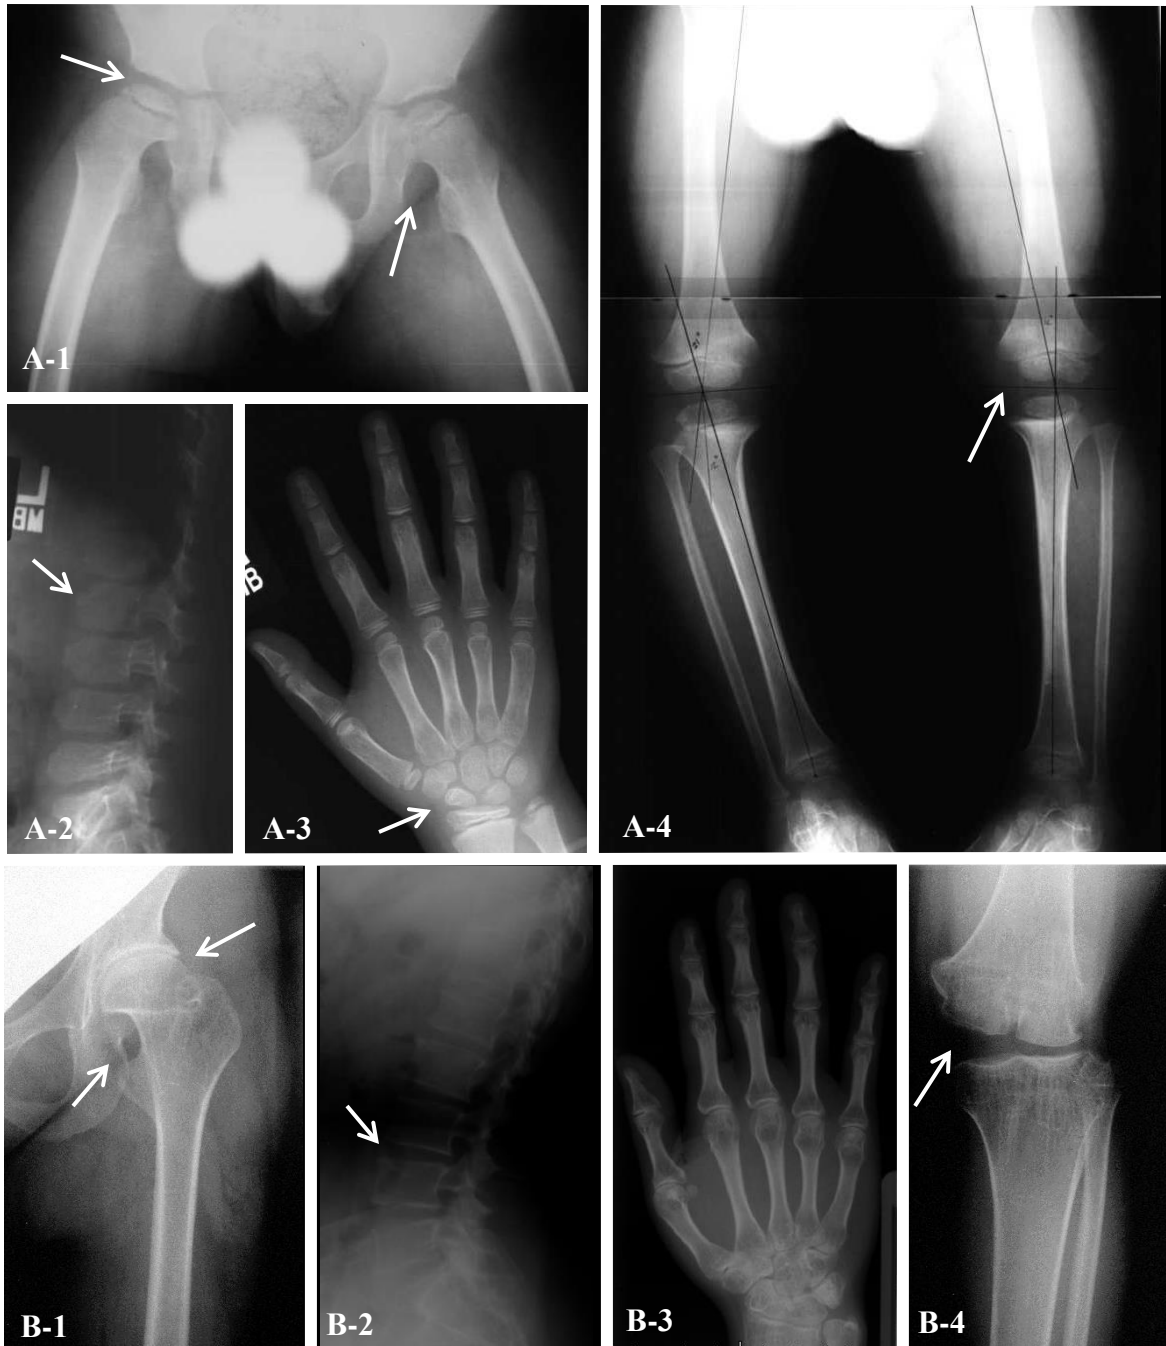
Radiographs of Patients with *CANTI* Mutations. A) Radiographs of patient R92-280A at age 8. A-1. AP pelvis shows flat capital femoral epiphyses with flat acetabulae (left arrow) and mild Swedish key appearance of the proximal femur, as indicated by the right arrow. A-2. Lateral lumbar spine showing platyspondyly and anterior wedging of the vertebral bodies, as indicated by the arrow. A-3. AP hand shows no structural abnormality, but carpal age is advanced by 2 years. A-4. AP knee showing small epiphyses with metaphyseal flare. B) Radiographs of patient R01-152A at age 25. B-1. AP right upper leg film shows epiphyseal dysplasia of the capital femoral epiphysis (right arrow) and a mild Swedish key, as indicated by
